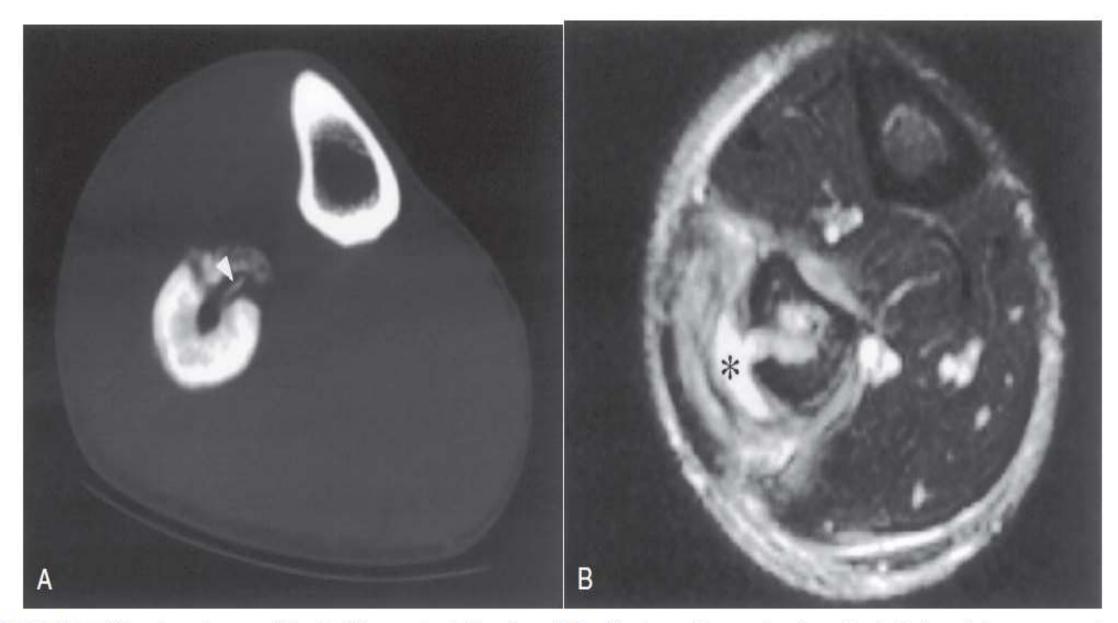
■ Chronic osteomyelitis. A, CT reveals thickening of the fibular cortex and a sinus tract that contains a sequestrum (arrowhead). B, T2-weighted axial MR image from a different level shows a lateral sinus tract through the cortex communicating with a soft tissue abscess (asterisk). Edema is surrounding the entire fibula. (Courtesy Leanne Seeger, MD.)
